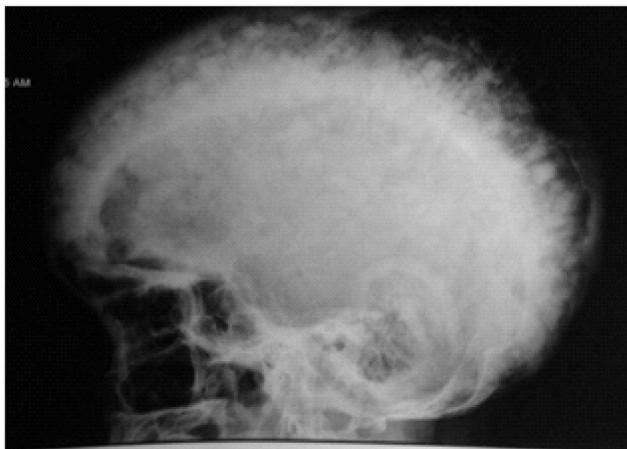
X-ray skull showing 'cotton wool spot' sign
